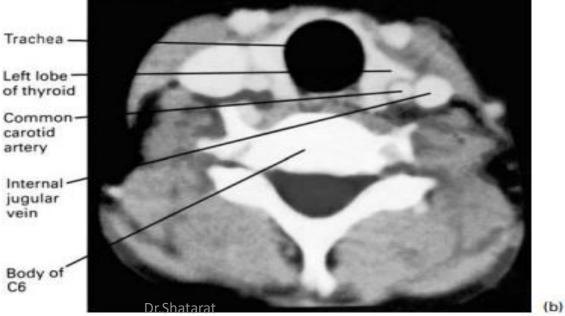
(a) Transverse section of the neck through C6—showing the fascial planes and also the contents of the pretracheal fascia (or 'visceral compartment of the neck'). (b) CT scan through the C6 level; compare this with the 4/2912020am.
